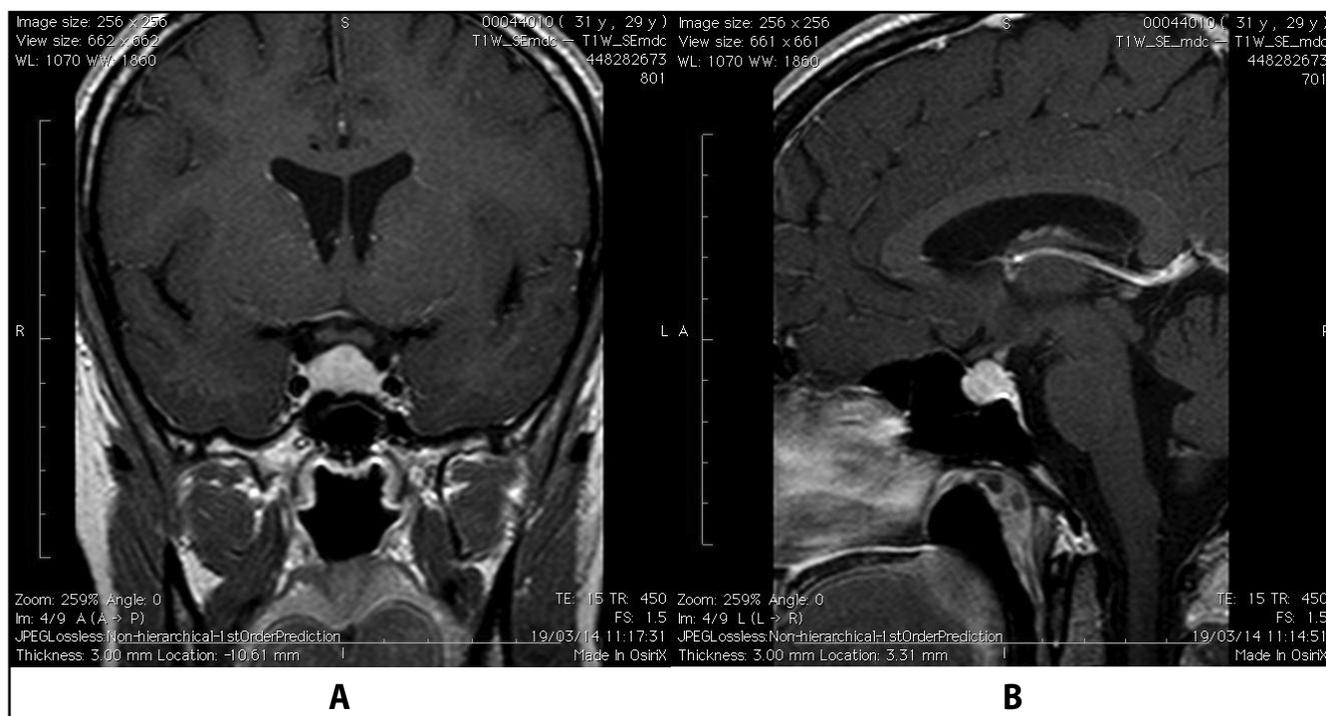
Initial pituitary Gd-DTPA enhanced MRI revealing pituitary left lobe enlargement. (A) Enhanced coronal image. (B) Enhanced sagittal image.
